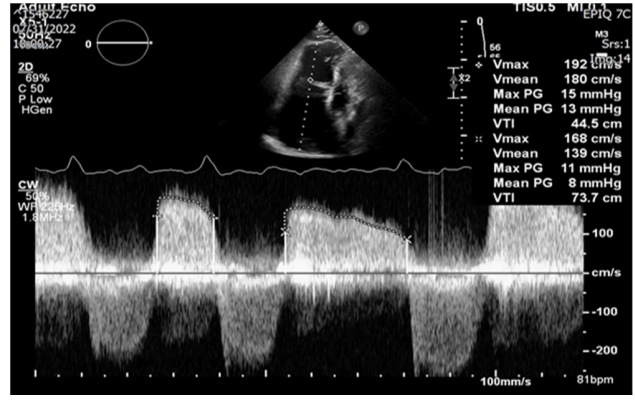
Transthoracic Echocardiography Showed Severe Tricuspid Stenosis with Mean Gradient = 11 mmHg and Pressure Half Time = 222 msec.
